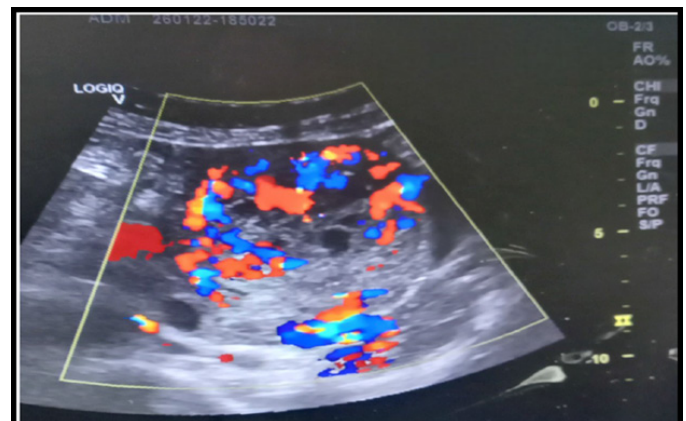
Ultrasound appearance of the highly vascularized invasive mole.
